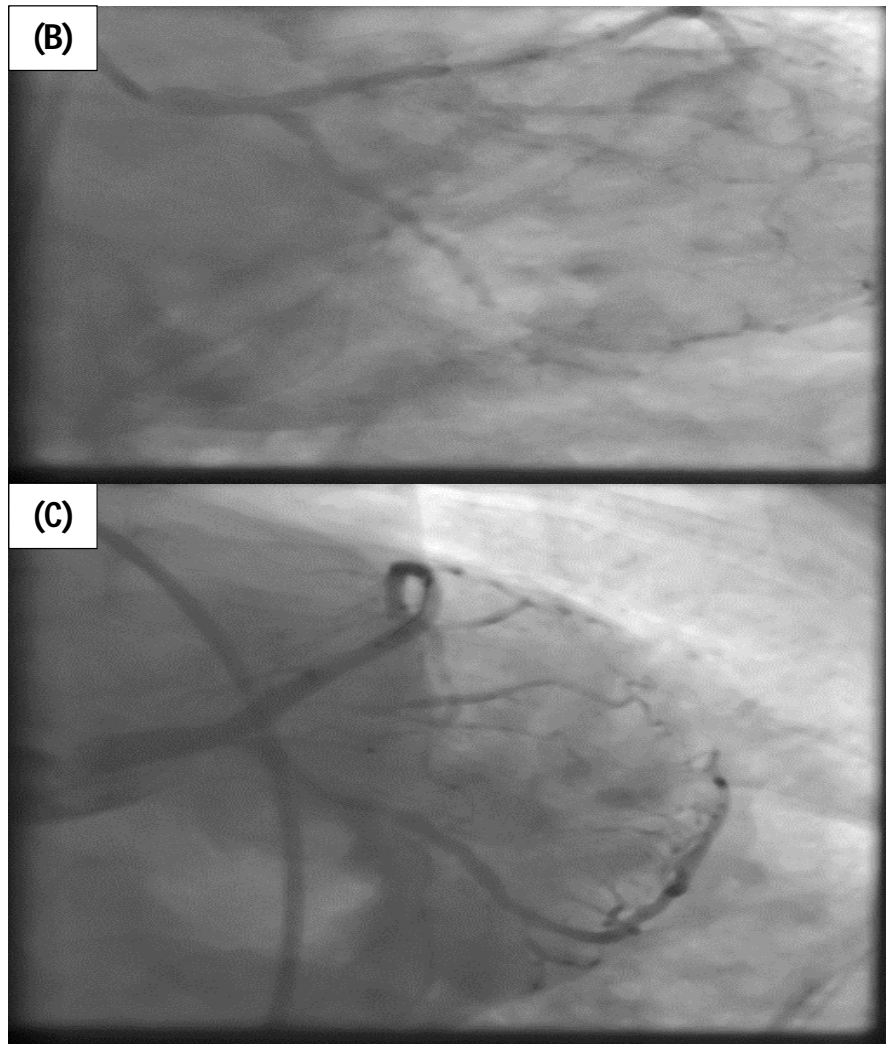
A) Speckle Tracking Echocardiography revealed marked impairment in the regional strains of the following myocardial segments (apical, apicoanterior, midanterior, basal anterior, basal anteroseptal, apico inferior, apicolateral and mid anterolateral). B) Diagnostic coronary angiography showing significant Left Main-proximal LAD lesion. C) Coronary Angiography after PCI and implantation of DES in Left main- LAD lesion.
